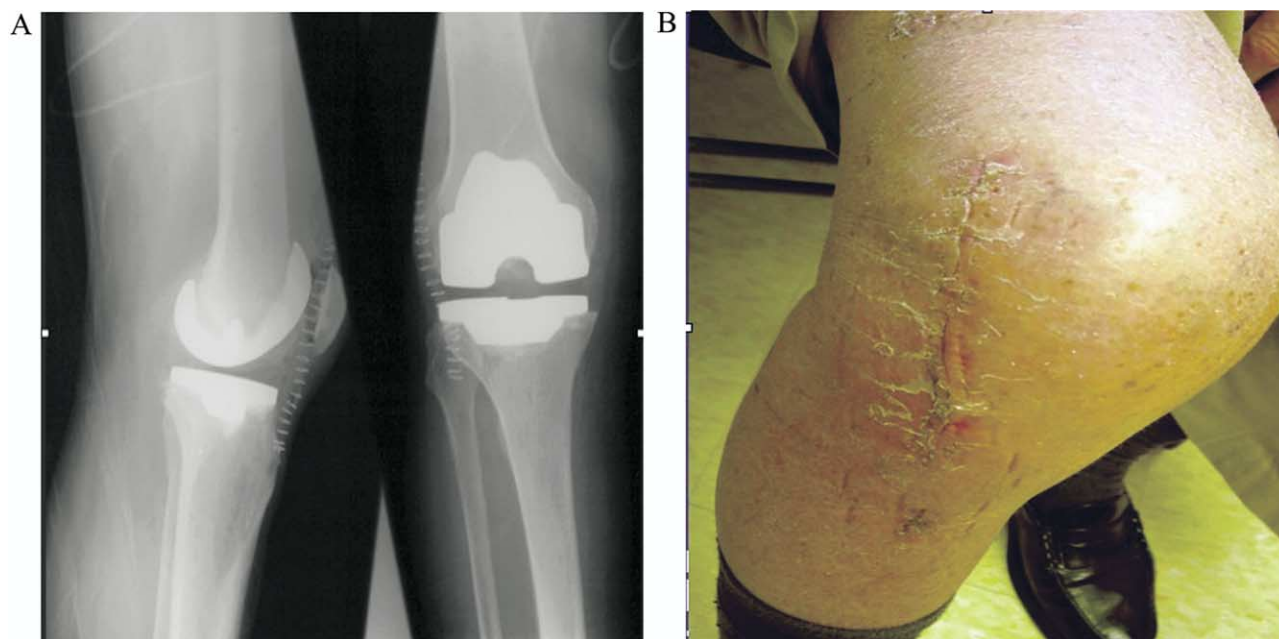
The incisions are usually less than 10 cm. Postoperative radiographs (A) and incision photographs (B) demonstrating the actual incision length. (Color version of figure is available online.)
